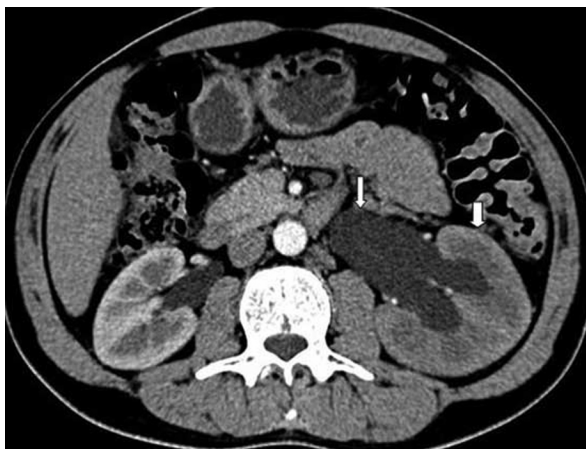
Case 2: 47-year-old male with IPT. Contrast-enhanced CT axial image shows the left-sided hydronephrosis (thin arrow) with asymmetric decreased renal parenchymal enhancement (thick arrow). The right kidney is normal.
